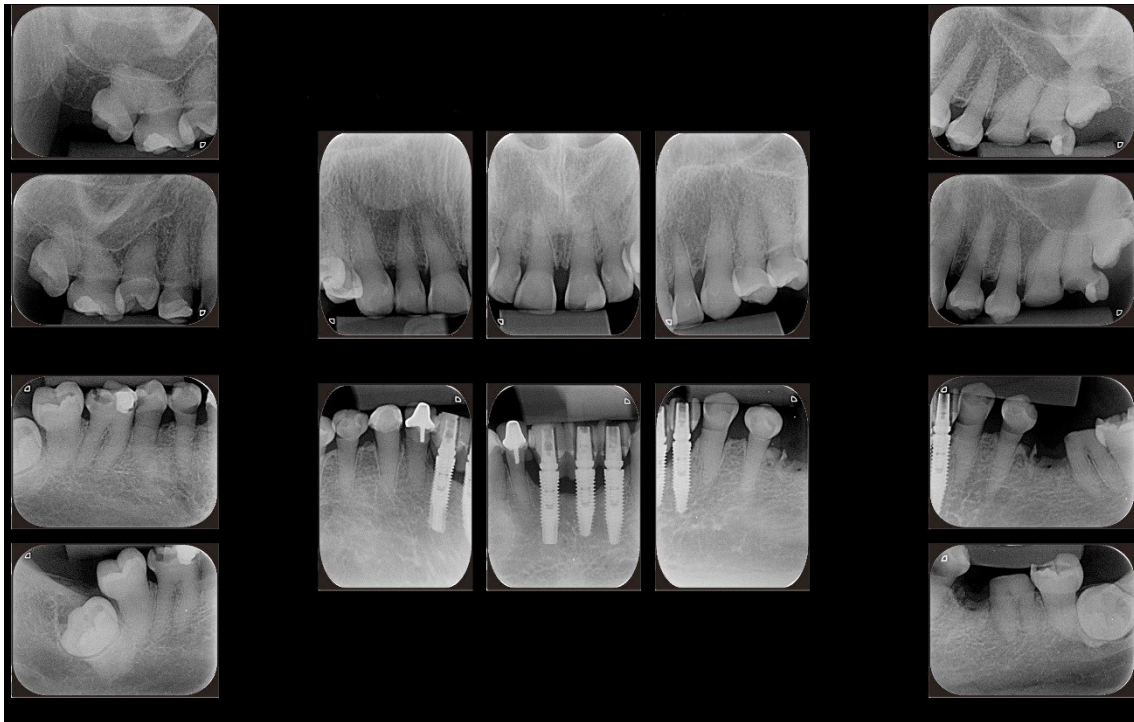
Periapical radiographic examination of the patient's entire mouth
